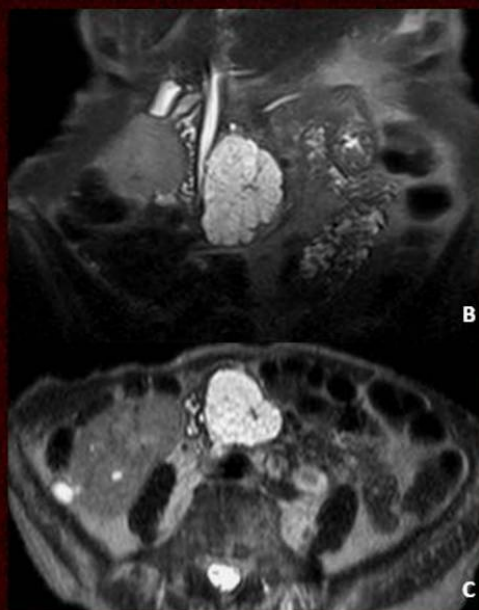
Serous cystadenoma in a 75-year-old female patient. (A) Enhanced-CT scan shows a lobulated microcystic mass in the uncinate process of the pancreas, which has multiple thin and enhancing septa. (B-E) Abdominal MR images (T2-weighted (B-C) and T1-weighted fat-suppressed before (D) and after (E) Gadolinium IV administration) in the same patient demonstrates the cystic mass with an internal honeycomb pattern. Note the slight enhancement of the septa after contrast administration (E).
